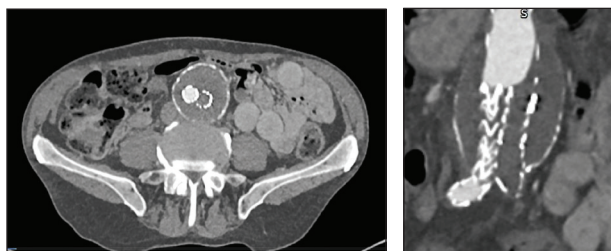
CTA demonstrating an occluded left EVAR limb.
